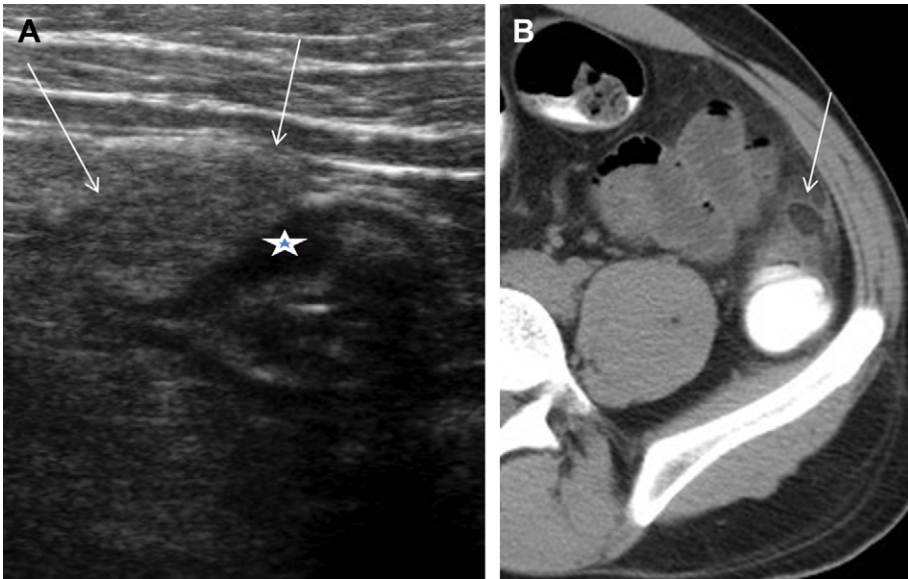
(A) Epiploic appendagitis—a fatty tender mass (*arrows*) adjacent to the left colon. Note the focal eccentric thickening of the outer layer of the left colon (*star*) indicating an adjacent inflammatory process rather than disease of the left colon itself. (B) Confirmed on CT (*arrow*).
